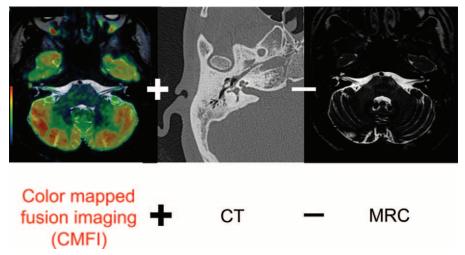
CMDWI-CT processing. The MRC data is stripped out from the original CMFI and imaging data from the original CT scan is incorporated to create a CMDWI-CT.
